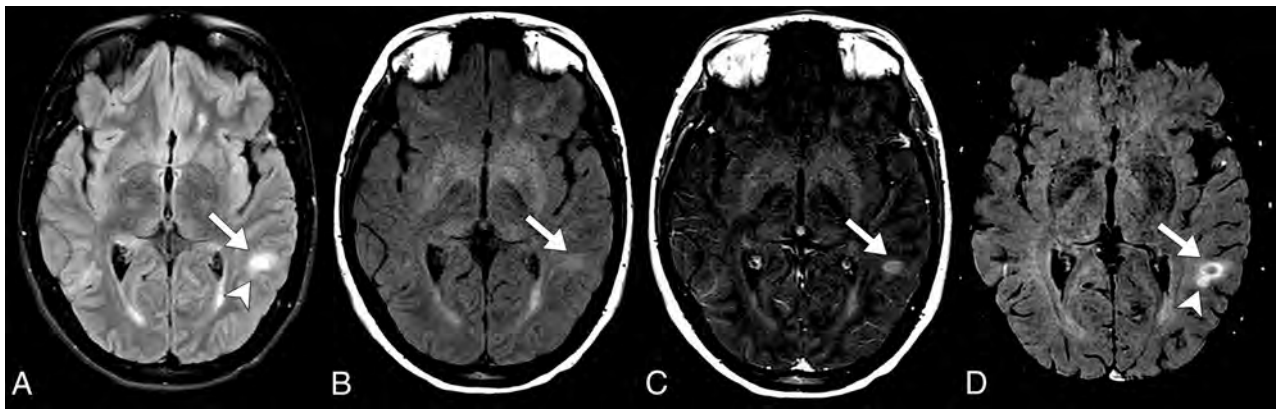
Axial fluid-attenuated inversion recovery sequence (A), axial T1 MTC pre- and postcontrast (B and C), and axial Gd-SWI sequence (D). A definitive acute demyelinating lesion requires the demonstration of a Gd-enhancing lesion along with high signal in the fluid-sensitive sequences, as shown in the left subcortical white matter temporal gyrus lesion (arrows). Note a small ovoid high-signal lesion on a FLAIR sequence adjacent to the aforementioned lesion, which demonstrates BBB dysfunction that is only characterized by the Gd-SWI sequence (arrowheads).
